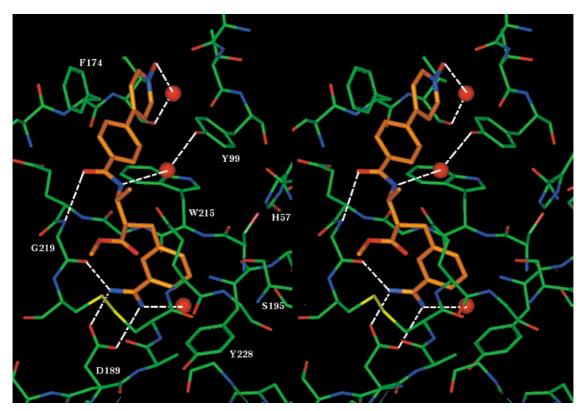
X-ray of FXV673 in Factor Xa. Red spheres represent bound water.
